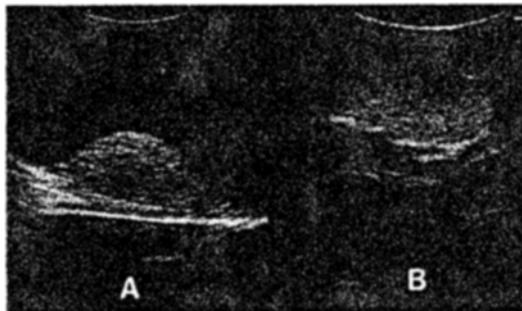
Ultrasonogram before (A) and after (B) sclerotherapy
